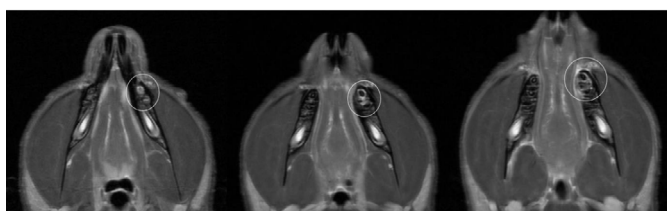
Successive coronal mandibular molar MRI sequences, time 30 days
